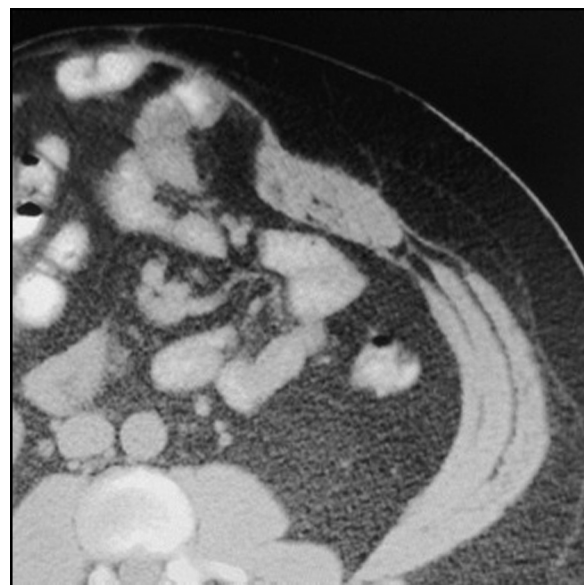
CT scan of a patient who had multiple previous abdominal component separations according to prior operative reports. All 3 components of the rectus sheath are intact and the patient benefited from a completion of release of the external oblique fascia.
